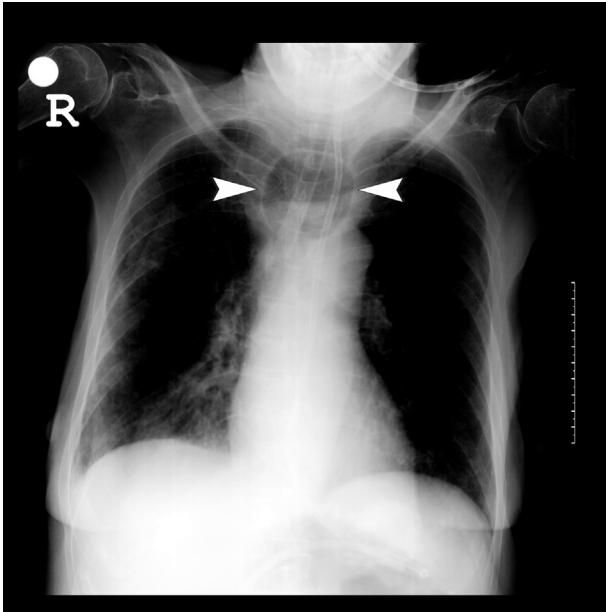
On plain thoracic X-ray, Tracheomegaly and cuff of endotracheal tube can be seen (arrow head).
